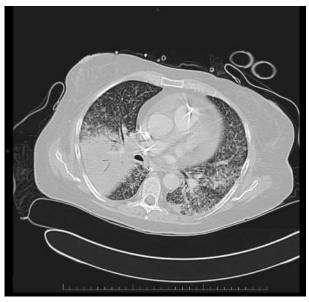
Chest computed tomography scan shows a right upper lobe consolidation, pericardial effusion without tamponade, and miliary airspace disease.
